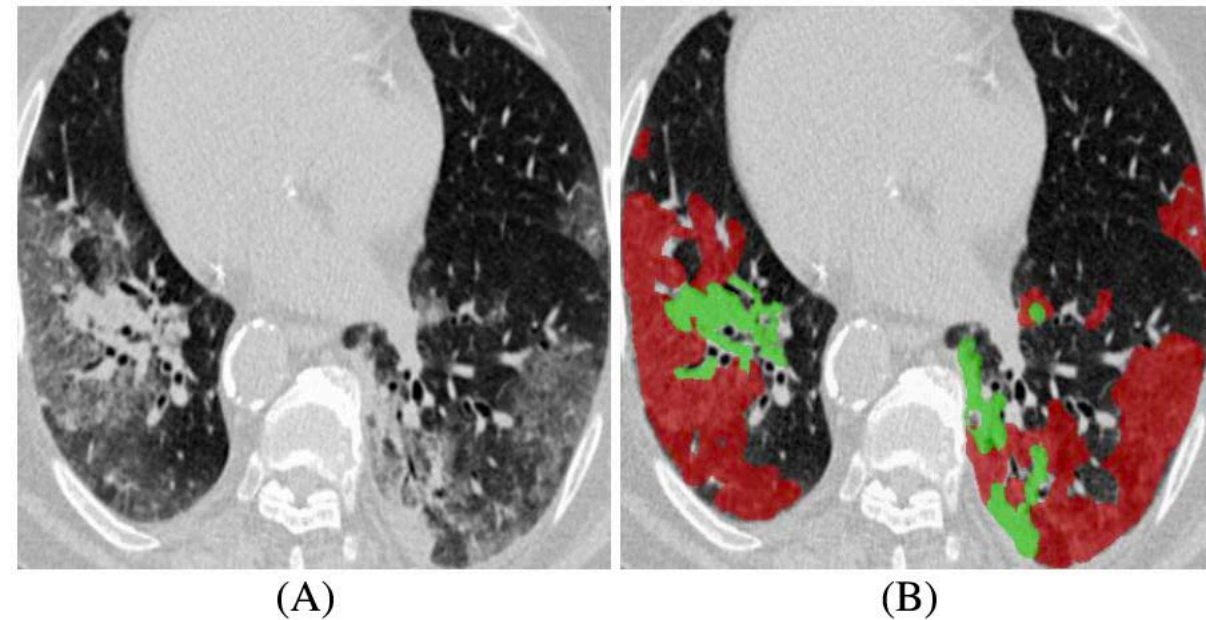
Example of COVID-19 infected regions (B) in CT axial slice (A), where the red and green masks denote the GGO and consolidation, respectively. The images are collected from [9].
